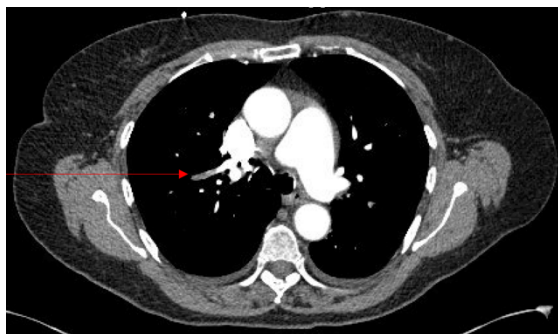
CT-PE chest with IV contrast showing filling defect in the right pulmonary artery involving the posterior segment of the upper lobe consistent with pulmonary embolism (red arrow pointing at the filling defect).
